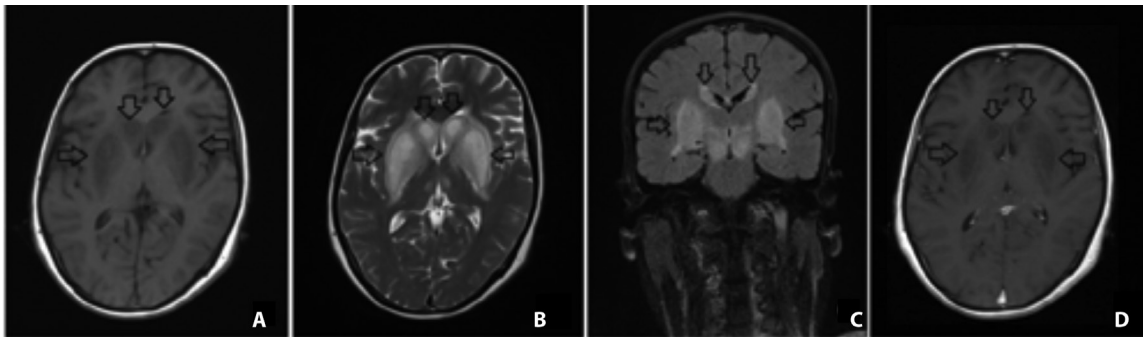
Magnetic resonance imaging; A) T1 axial, B) T2 axial, C) FLAIR coronal, D) T1 contrast axial: Lesions in the bilateral basal ganglia are symmetric and hyperintense in T2 and FLAIR-weighted imaging and hypointense in T1-weighted imaging, and there is no pathologic contrast enhancement.
